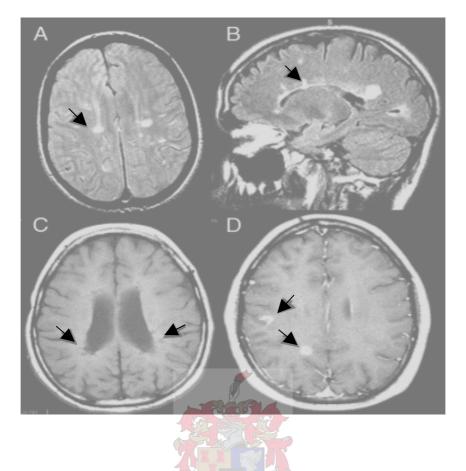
MRI scans of patients with RRMS. Images A and B (arrows indicate) show inflammation characteristic of MS. The inflammation can be seen as 'hyperintensities' with detection thereof allowed for by the fluid-attenuated inversion recovery (FLAIR); Figure C shows 'black holes'/
